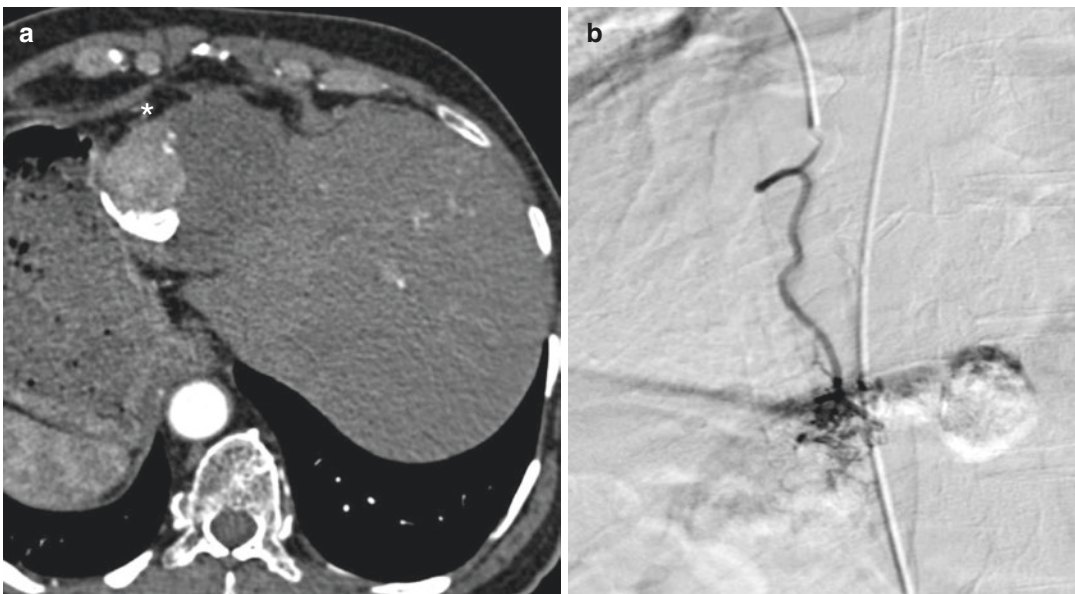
(a) A 75-year-old HbsAg positive case of HCC, with situs inversus, post-three sessions of TACE, CT scan shows residual enhancement [*]. (b) Extrahepatic
